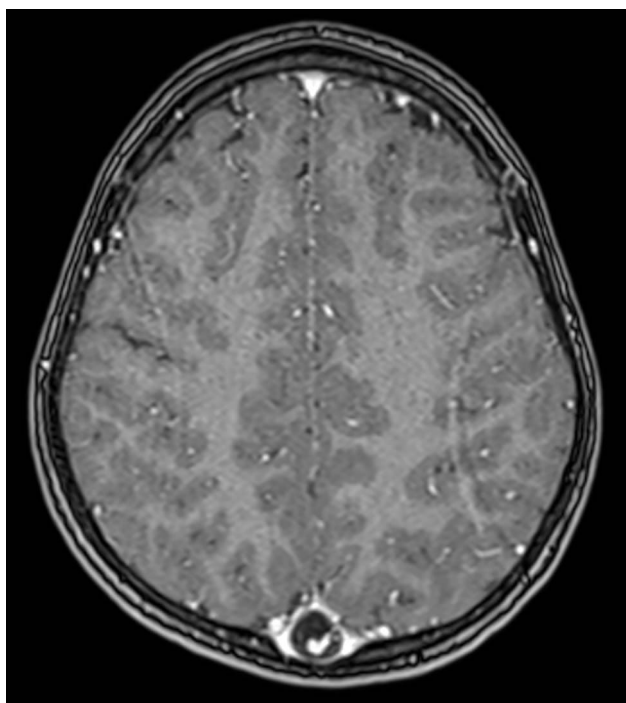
Magnetic resonance images of the patient with abnormal sagittal sinus (top view).
